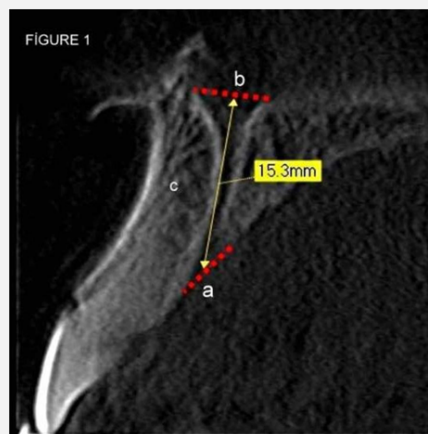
The sagittal section shows the measurements of the length of the nasopalatine canal and the anteroposterior diameter of the canal at the nasal fossa, mid-level, and hard palate. Measurements of the incisive foramen, nasopalatine foramen and incisive canal length on sagittal section CBCT; a) The diameter of the incisive foramen, b) the diameter of the nasopalatine foramen, c) The length of the nasopalatine canal
